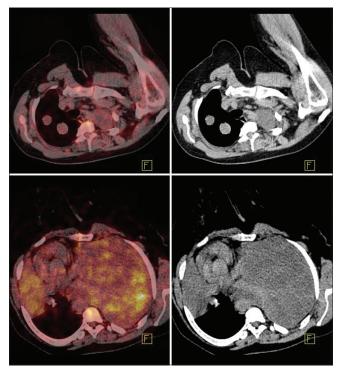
Positron emission tomography-computed tomography fusion and plain computed tomography scan axial images show large lesion with inhomogeneous density and internal necrotic areas and heterogeneous fluorodeoxyglucose uptake completely occupying left hemithorax with displacement of mediastinum. Similar fluorodeoxyglucose-avid right middle lobe and nonfluorodeoxyglucose-avid two right upper lobe lesions
